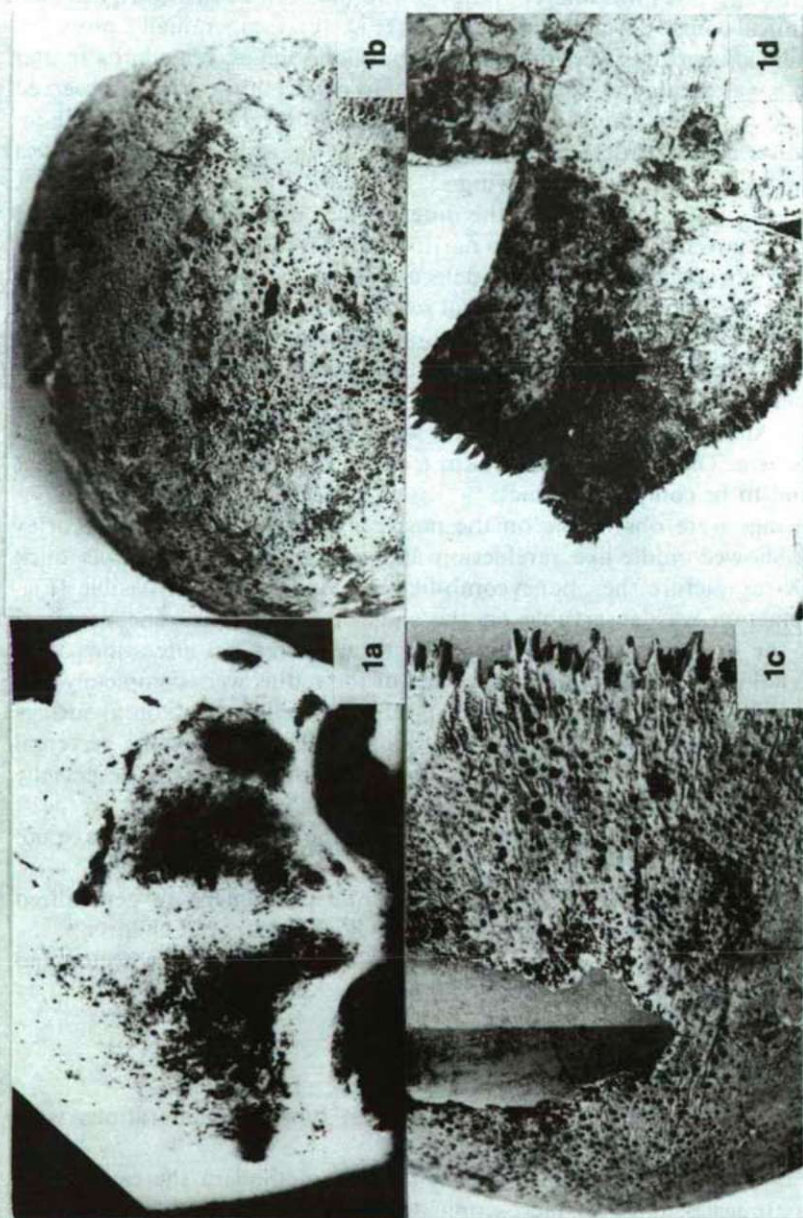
The expansion of the diploe space and the thinning of the cortex are well visible on the X-ray picture of the frontal bone
